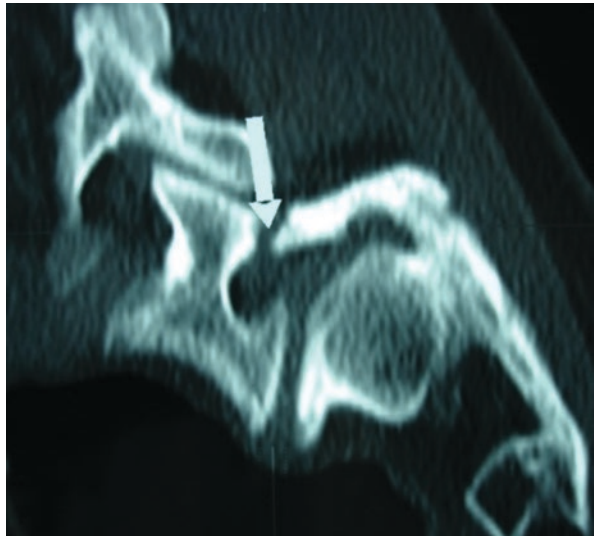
Sagittal CT view demonstrating spondylolysis of a dysplastic L5 isthmus
